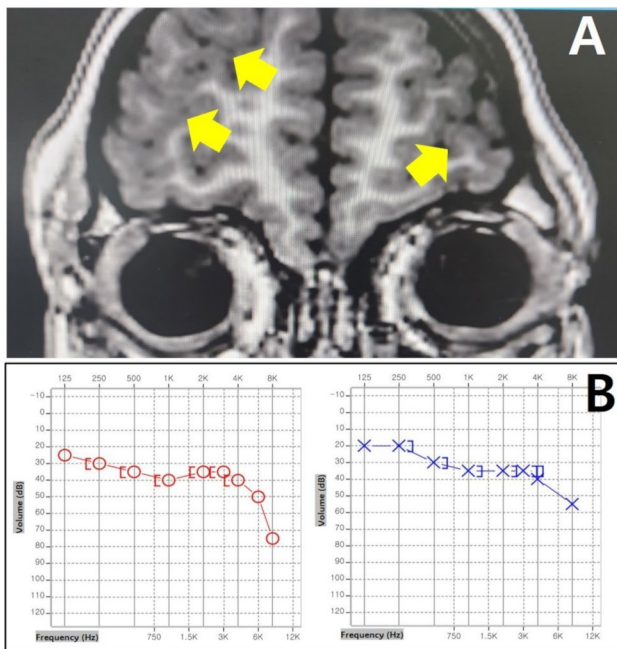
Brain MRI and pure-tone audiometry of a patient. (A) T1 coronal view shows abnormal thickening of bifrontal cortex (yellow arrow). (B) Pure-tone audiometry revealed bilateral sensorineural hearing loss
